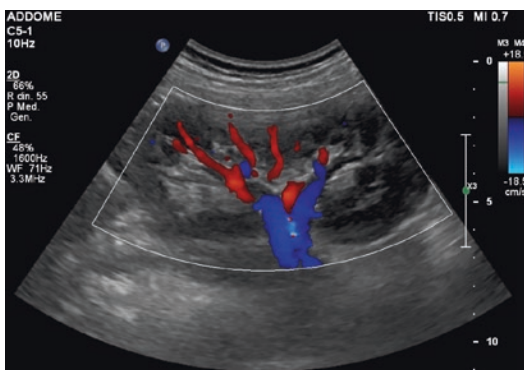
Color Doppler image of native kidney with normal intraparenchymal vascularization
